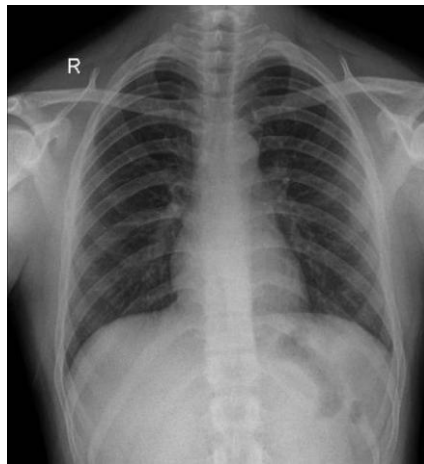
Chest X-Ray (Anteroposterior View, 22/01/2026)
